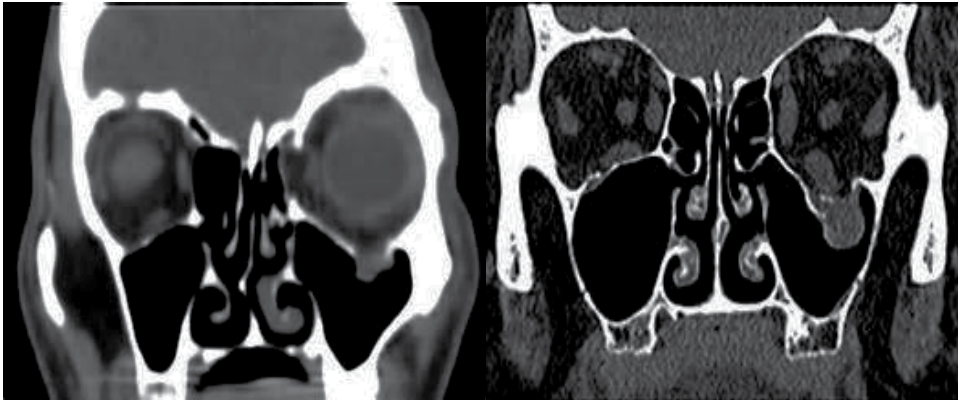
Coronal CT views of left orbital blow-out fracture
